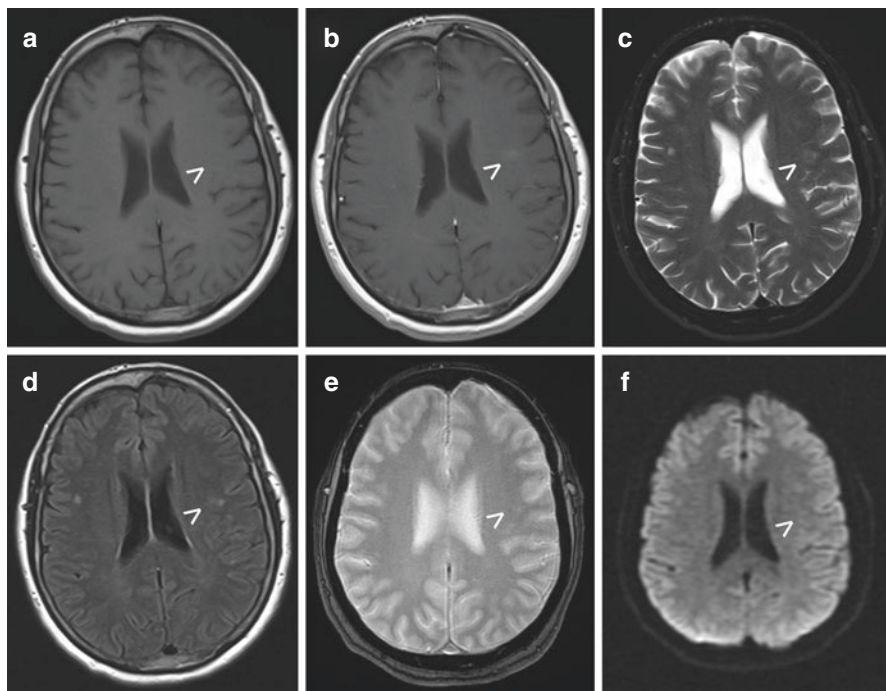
An incidentally-diagnosed, left frontal (centrum semiovale) BCT is demonstrated in a 14-year-old boy. Non-contrast head CT showed no clear abnormality (not shown). Axial MR imaging demonstrates a lesion that is isointense to gray matter on T1-weighted sequences (a; *arrowhead*) with faint, brush-like, gadolinium enhancement (b; *arrowhead*), slightly hyperintense on T2-weighted (d; *arrowhead*) and fluid-attenuated inversion recovery (FLAIR) (e; *arrowhead*) sequences, and exhibits a subtle, punctate area of hypointensity on T2*/gradient echo sequences (f; *arrowhead*). MR angiography (time-of-flight) was normal (not shown). This abnormality was noted to be stable on serial MR imaging studies over a period of 10 years
